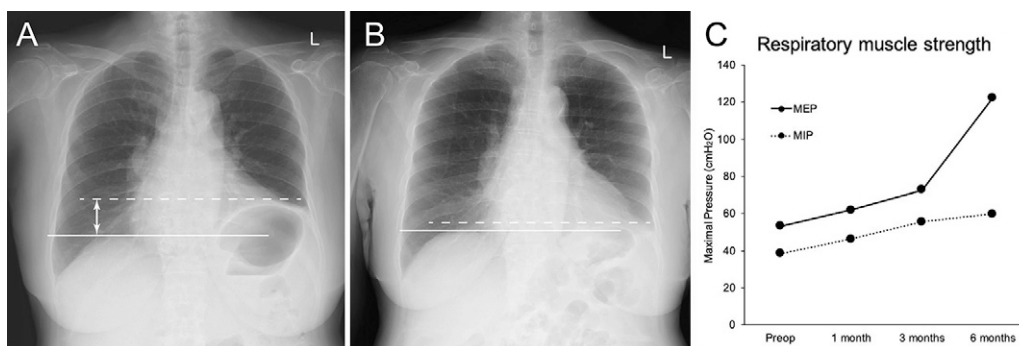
A: Preoperative inspiration chest radiograph shows that the left diaphragm (dashed line) is elevated (double arrow) in comparison to the right diaphragm (solid line). B: The left diaphragm elevation has resolved on postoperative inspiration chest radiograph. C: Respiratory muscle strength graph showing that compared to the preoperative condition (preoperative), respiratory muscle strength increased at 1, 3, and 6 months after surgery.
